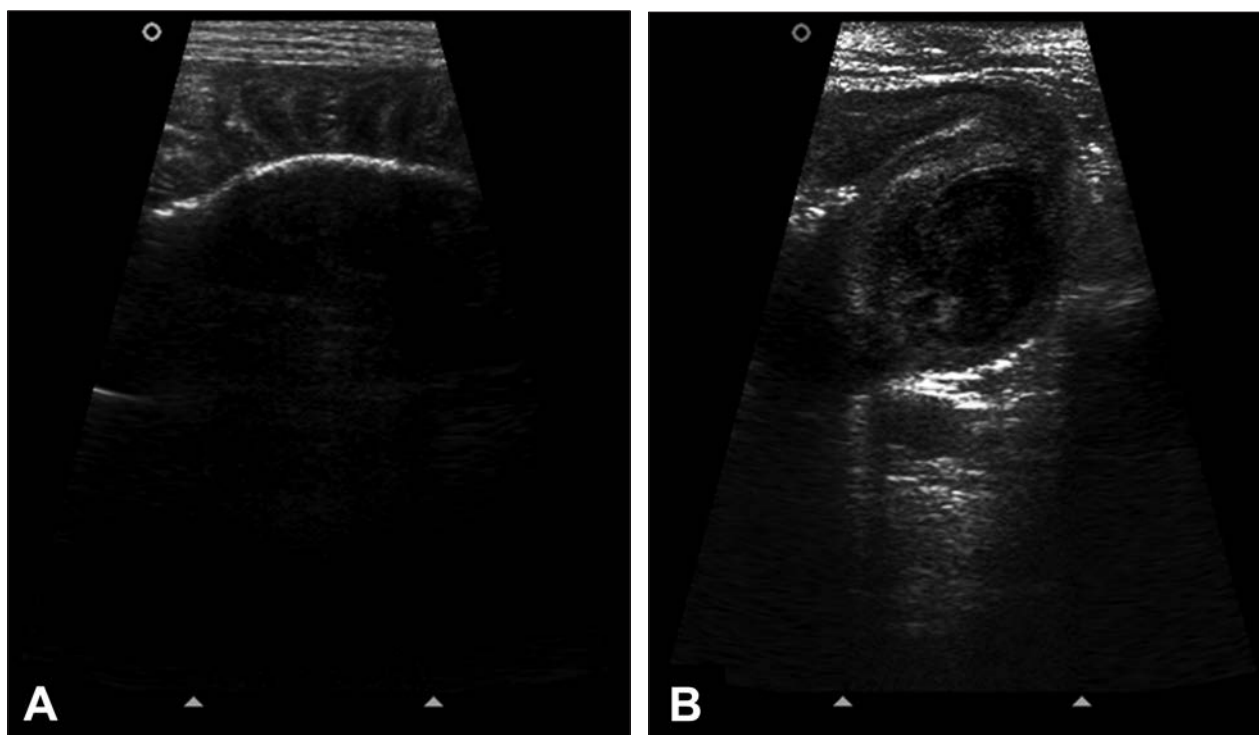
Longitudinal ultrasonographic images of the small intestine of a 2-year-old English Bulldog with a 4-day history of inappetence and vomiting. Images were obtained via a transabdominal approach with a 10-MHz linear transducer.
